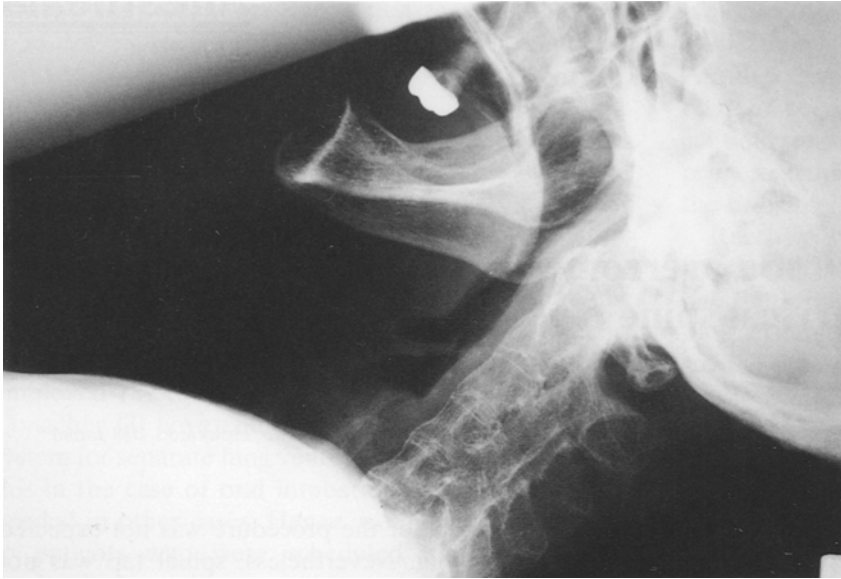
Lateral roentgenogram of the fusion of cervical supine. The occiput of the patient could not touch the bed while she was lying on her back
